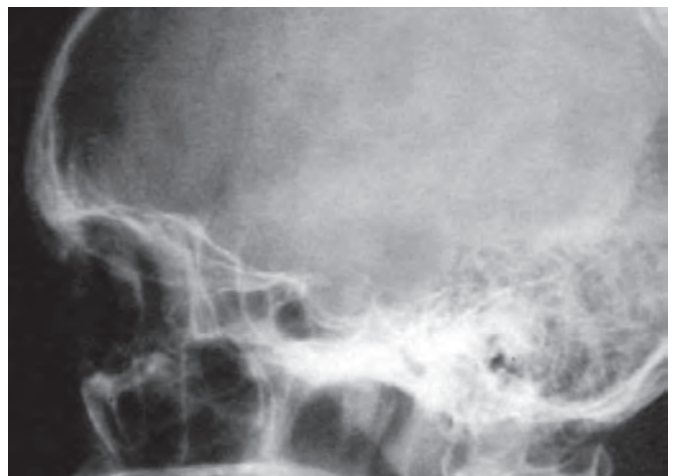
X-ray lateral view in a patient with pituitary adenoma showing double flooring of the sella
